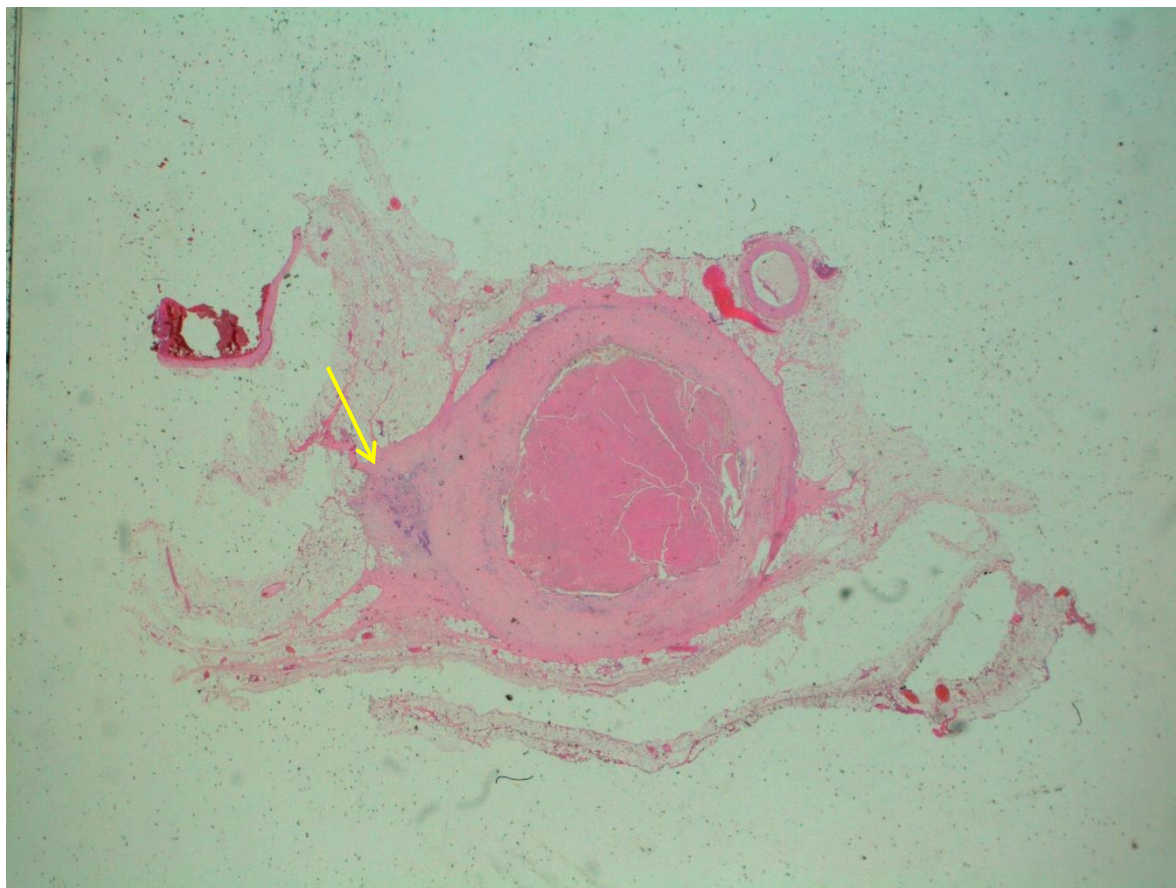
(Case 168): Three pathological lymph nodes, all with capsular rupture (yellow arrow), were found in this 51-year old male patient with a ypT3N1b after neoadjuvant treatment for a cT3Nx upper rectal tumour; the lymph nodes were not seen in the baseline MRI
